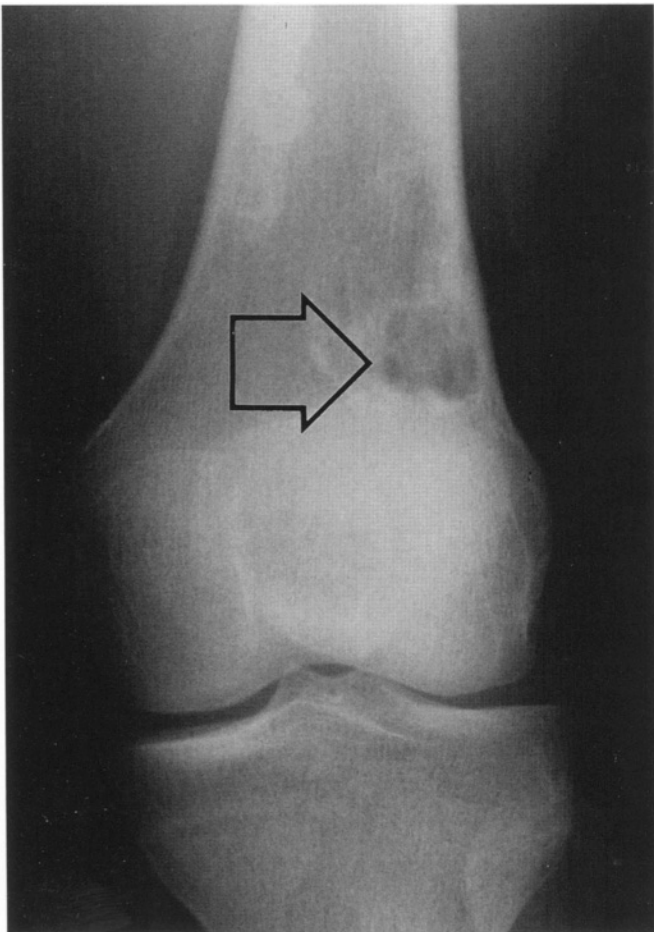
Nonossifying fibroma (NOF) of the distal femur (arrow). As in most cases of NOF, the lesion was asymptomatic and the plain radiographs were ordered because of a trauma to the knee.
